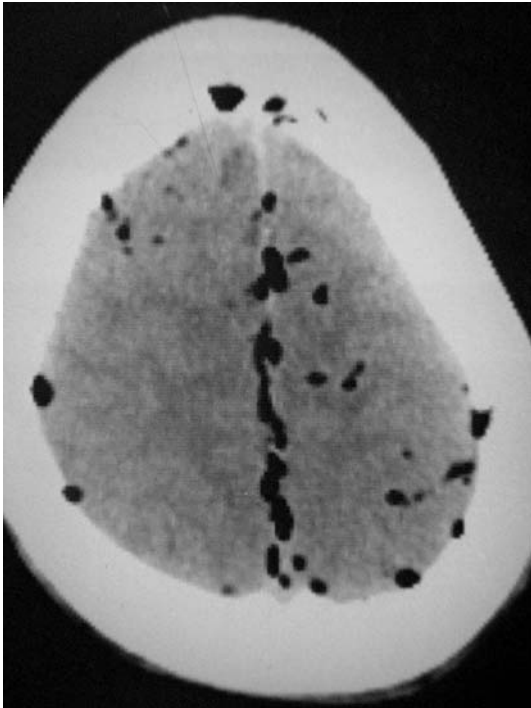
Cranial CT shows widespread pneumocephalus in the subarachnoid spaces at the frontoparietal and inter-hemispheric locations
